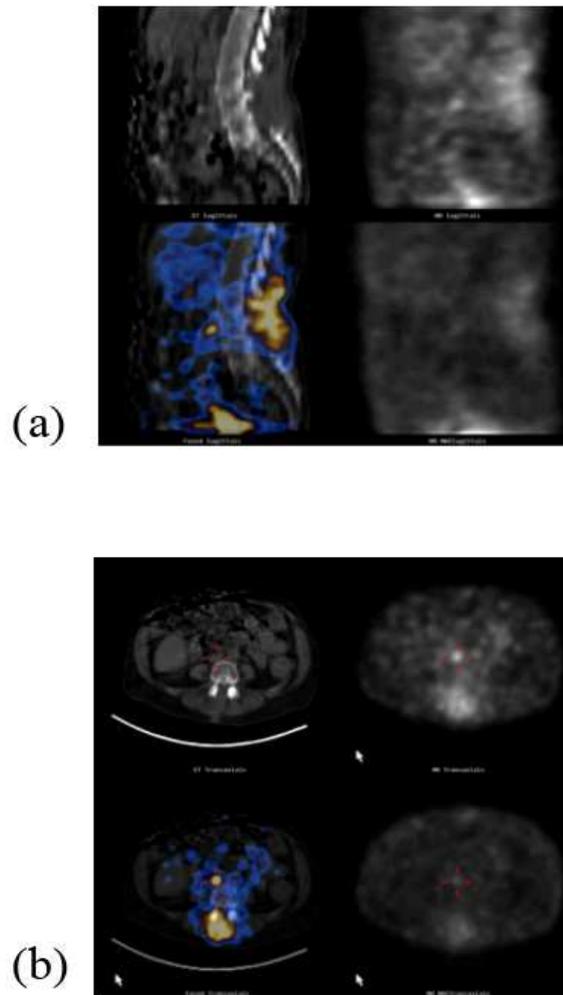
Patient with *St. aureus* post-surgical infection involving the posterior soft tissues adjacent to the L3-L5 lumbar tract, with ^{111}In -Biotin accumulation at the site of infection and in the corresponding abdominal lymph node, without bone involvement. (a): sagittal SPECT, CT, and fused sections. (b): transaxial SPECT, CT, and fused sections
